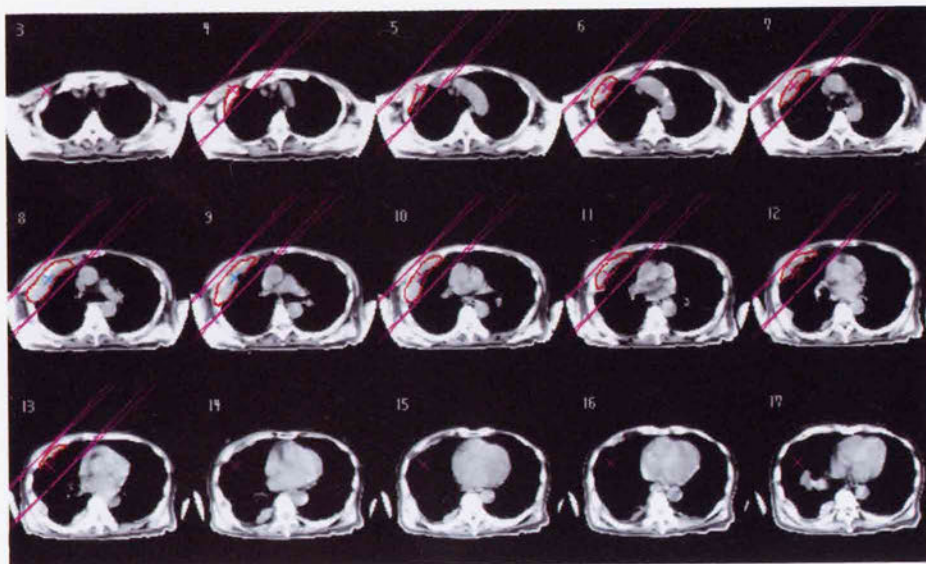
Calculated beam image shown on each CT axial image.
